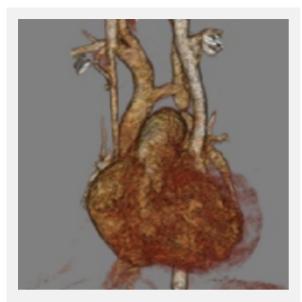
CT Angiography 3D reconstruction image. fourmonth old; aortic coarctation + arcus hypoplasia.
